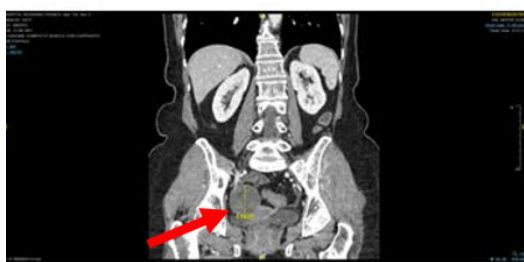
Abdominal CT scan showing appendix dilation.
